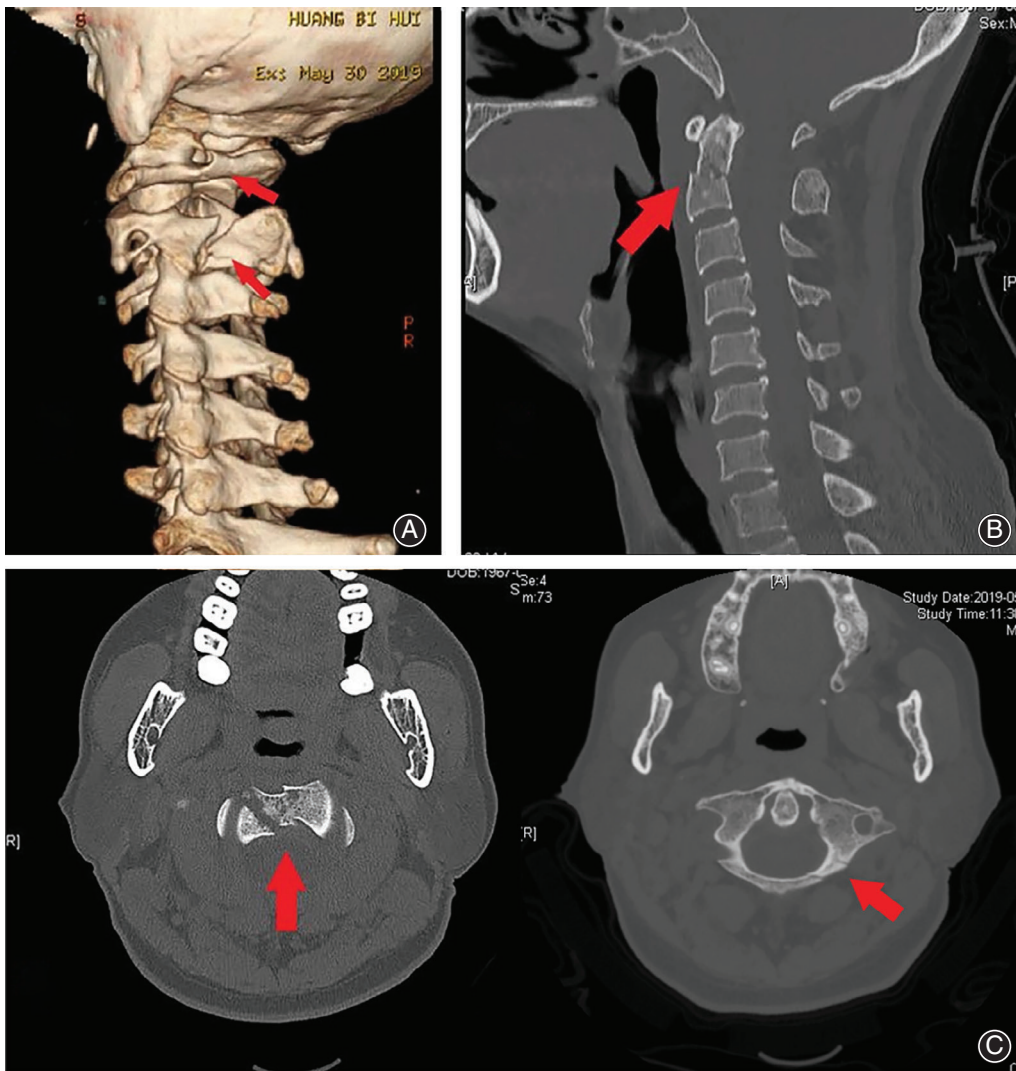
CT and 3D-CT showed multiple complex fractures of atlas and epistropheus (arrows).
